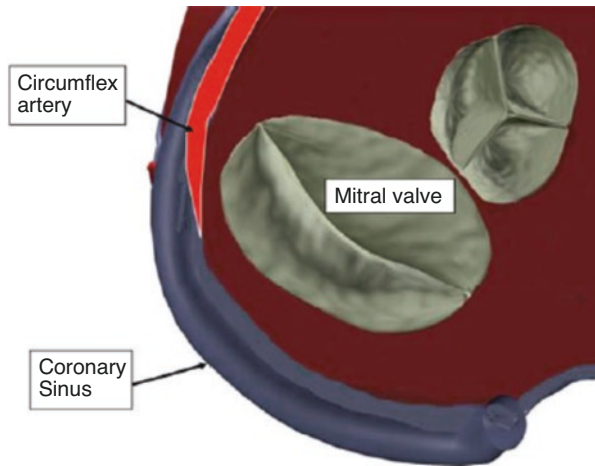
Anatomic relationship between coronary sinus and mitral valve annulus, as shown by computed tomography imaging in human
